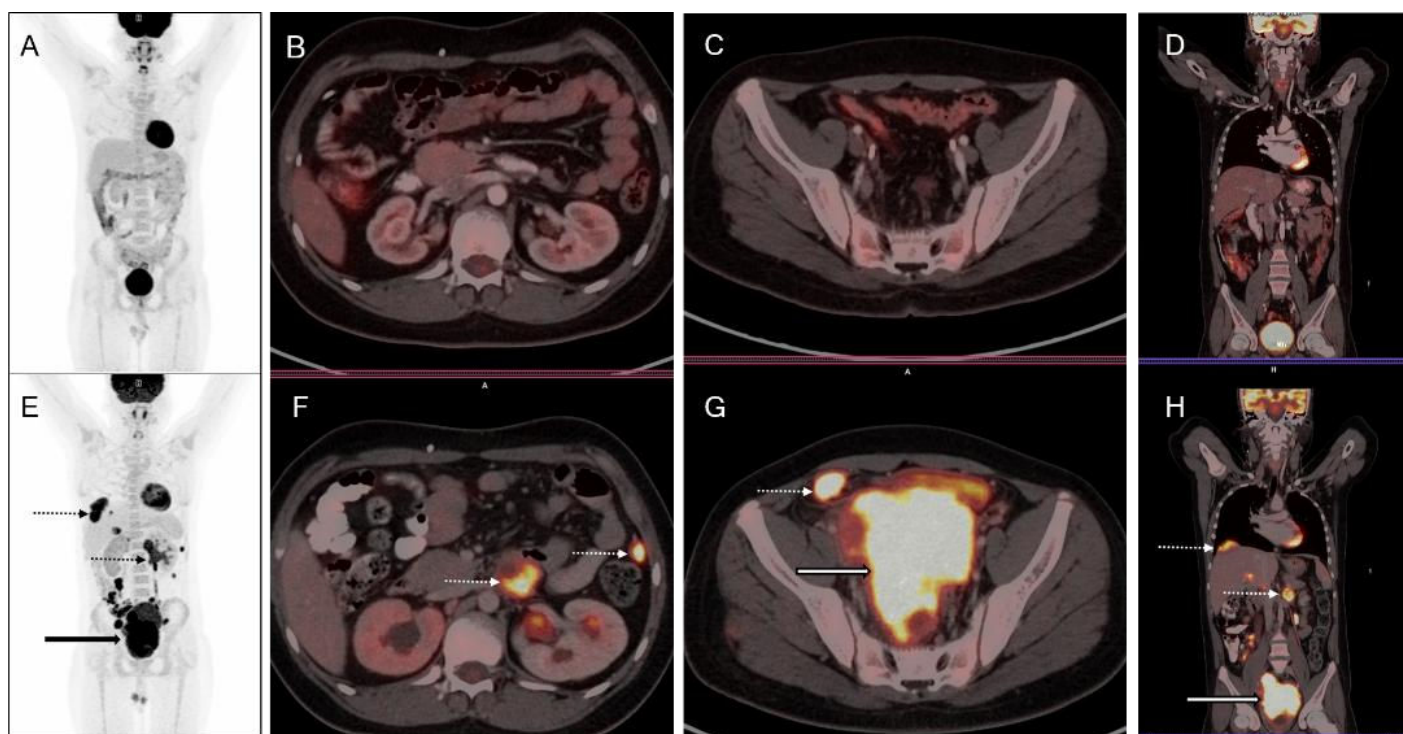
Baseline whole-body FDG PET-CT scan (E-H) in a known case of CNS Germinoma demonstrates a large coalescent mass (arrow) in the pelvis compressing rectum and urinary bladder with focal loss of fat planes, along with multiple FDG avid discrete and coalescent necrotic omental, peritoneal, serosal and liver surface deposits (dotted arrow). Follow-up whole body PET-CT scan (A-D) done after 08 weeks demonstrates interval resolution of these lesions suggestive of complete metabolic response to treatment.
